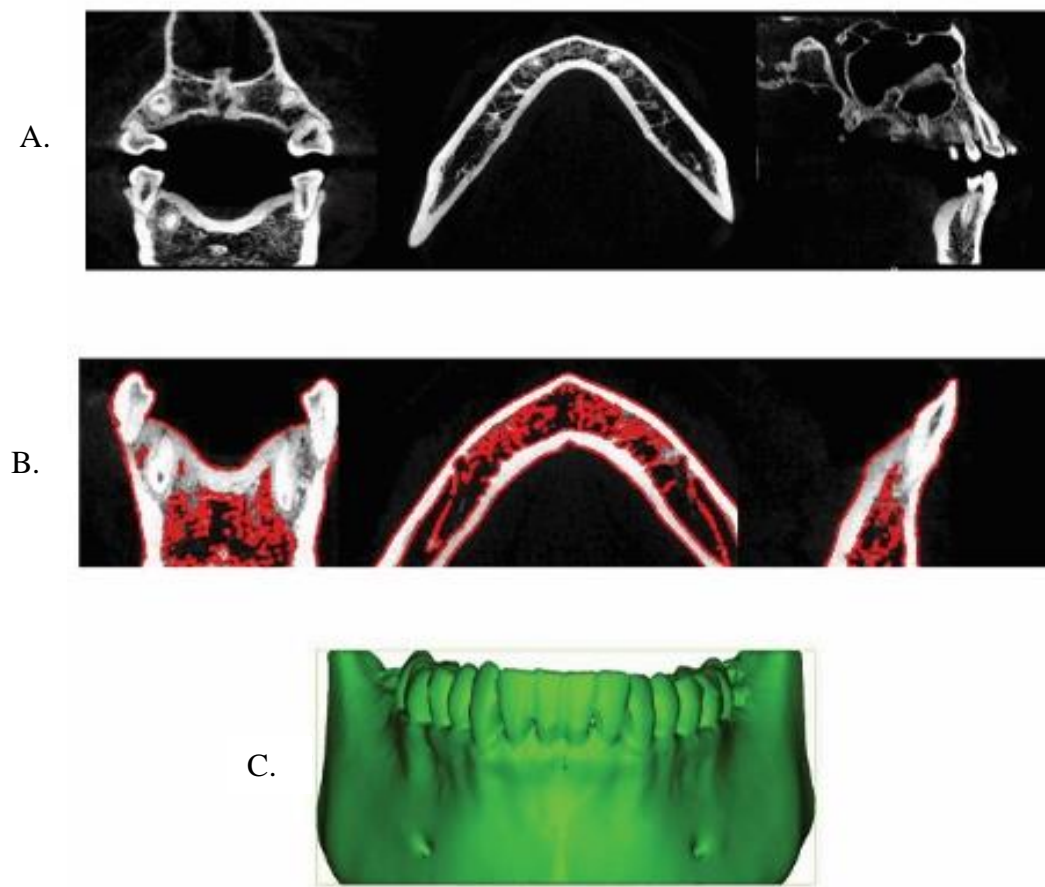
Reconstruction of cone beam computed tomography-derived mandibular cast A, CBCT dataset, B. combination of manual and automatic thresholding applied to the mandibular region. C, segmented mandible.
